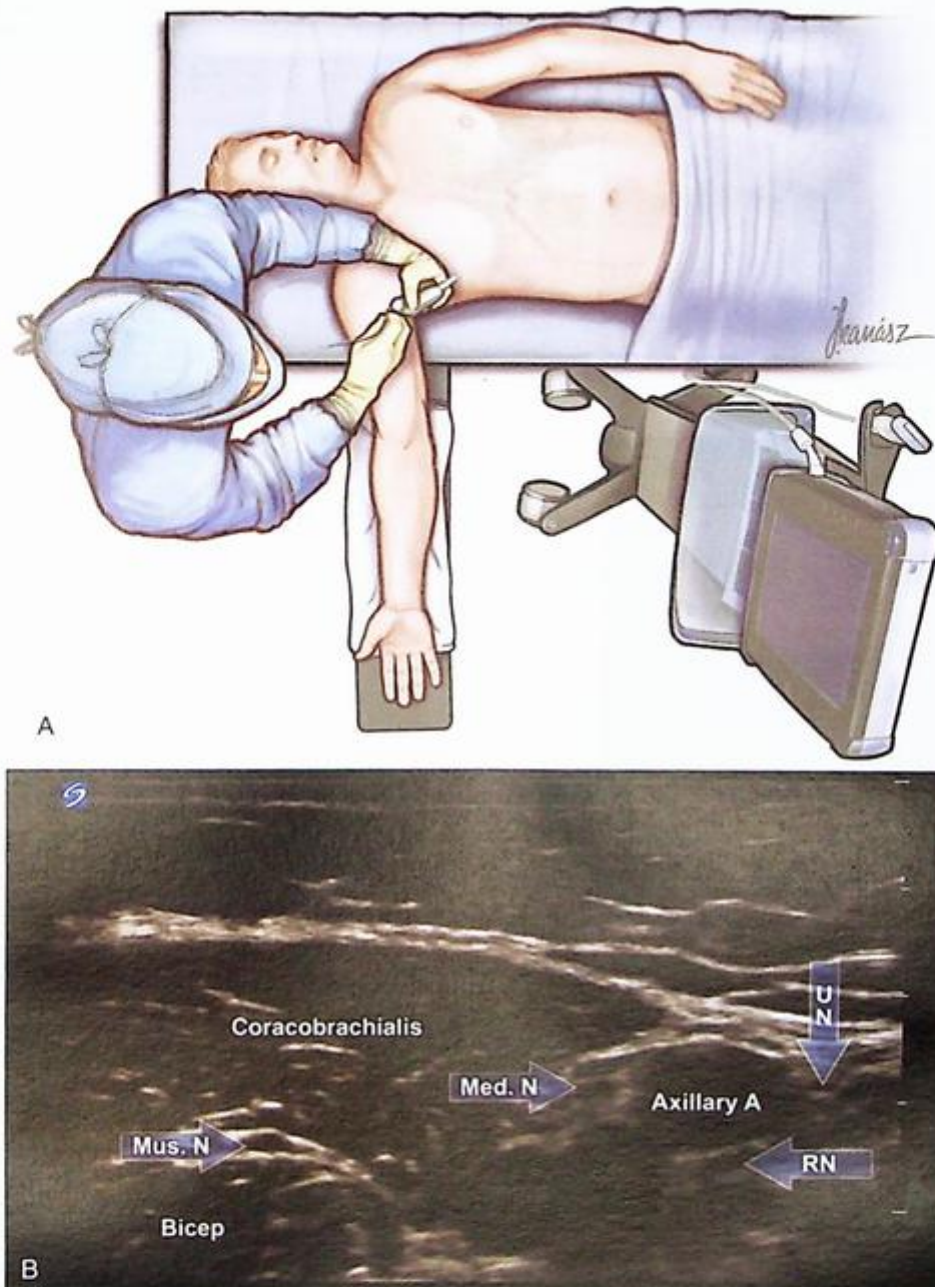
(A) Operator positioned behind the patient with the ultrasound machine facing the operator. (B) Sonoanatomy for the axillary brachial plexus block. *Med. N*, Median nerve; *Mus. N*, musculocutaneous nerve; *RN*, radial nerve; *UN*, ulnar nerve.
